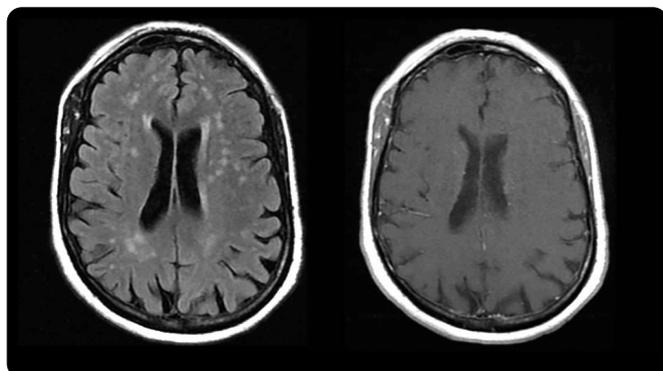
MRI, axial FLAIR and spin echo with T1 information and with contrast medium: multiple hyperintensities in the periventricular white matter, bilateral semioval and subcortical centers, these lesions do not enhance with the administration of contrast medium and may correspond to age-related changes. No pachy- or leptomeningeal relay is observed.
